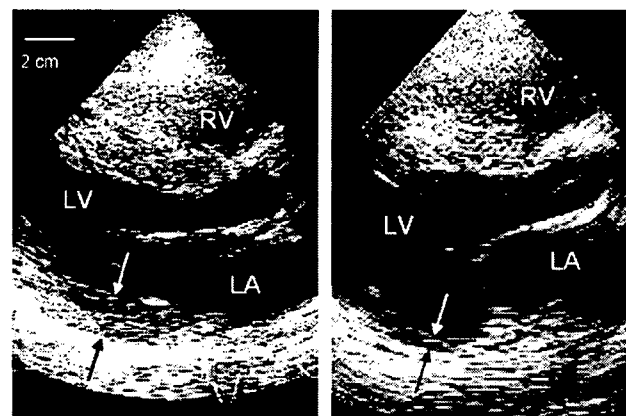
Serial echocardiograms of a patient with cardiac Fabry's disease at 57 (left) and 63 (right) years old. Ventricular septal and posterior wall thicknesses changed from 21 and 18 to 19 and 7 mm, respectively, with the development of CHF. LA = left atrium; LV = left ventricle; RV = right ventricle.
